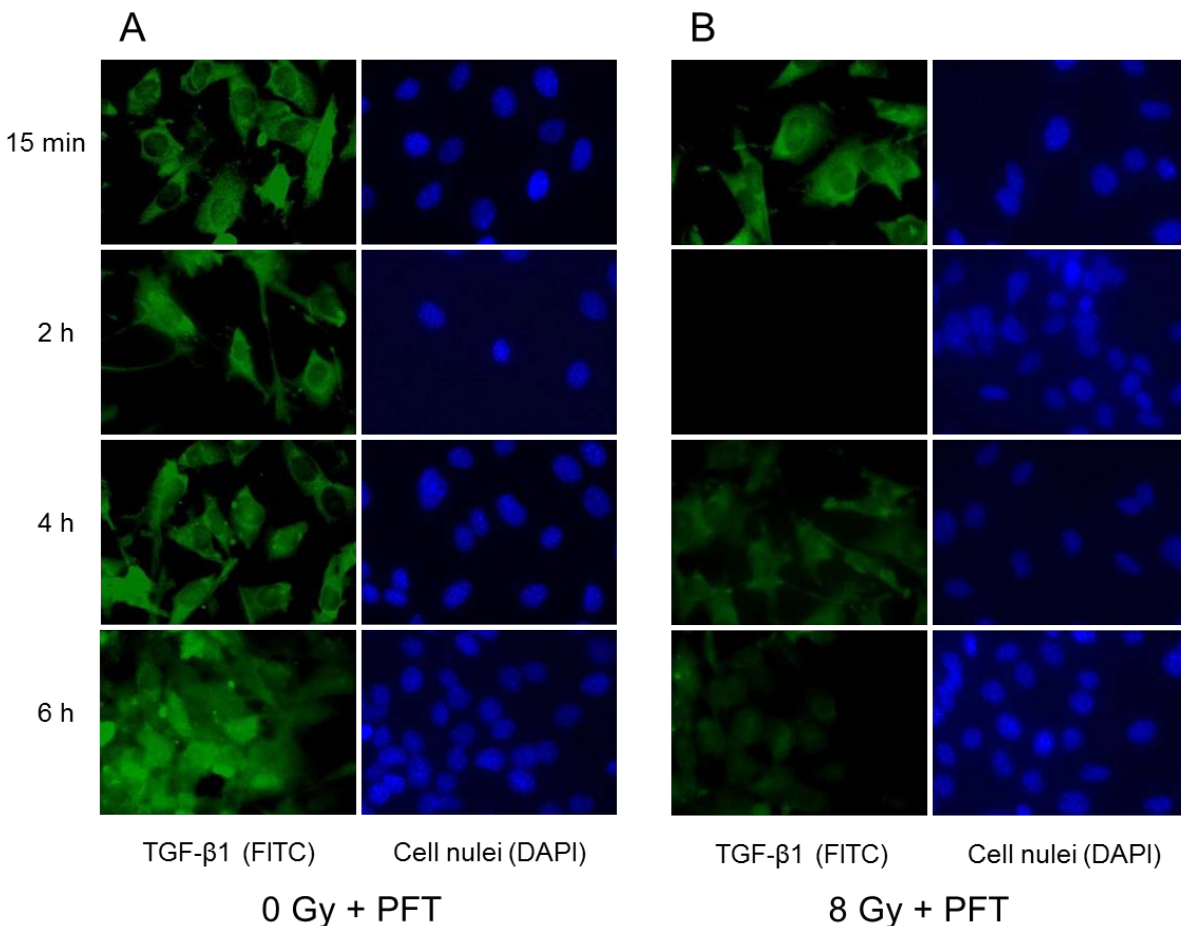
TGF-β1 expression in OCT-1 cells after X-ray exposure in presence of cyclic pifithrin-α
